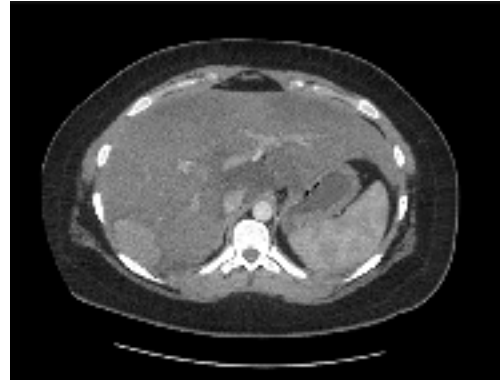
Computed tomography after stopping oral contraceptive pills for 3 mo. No change in size.
